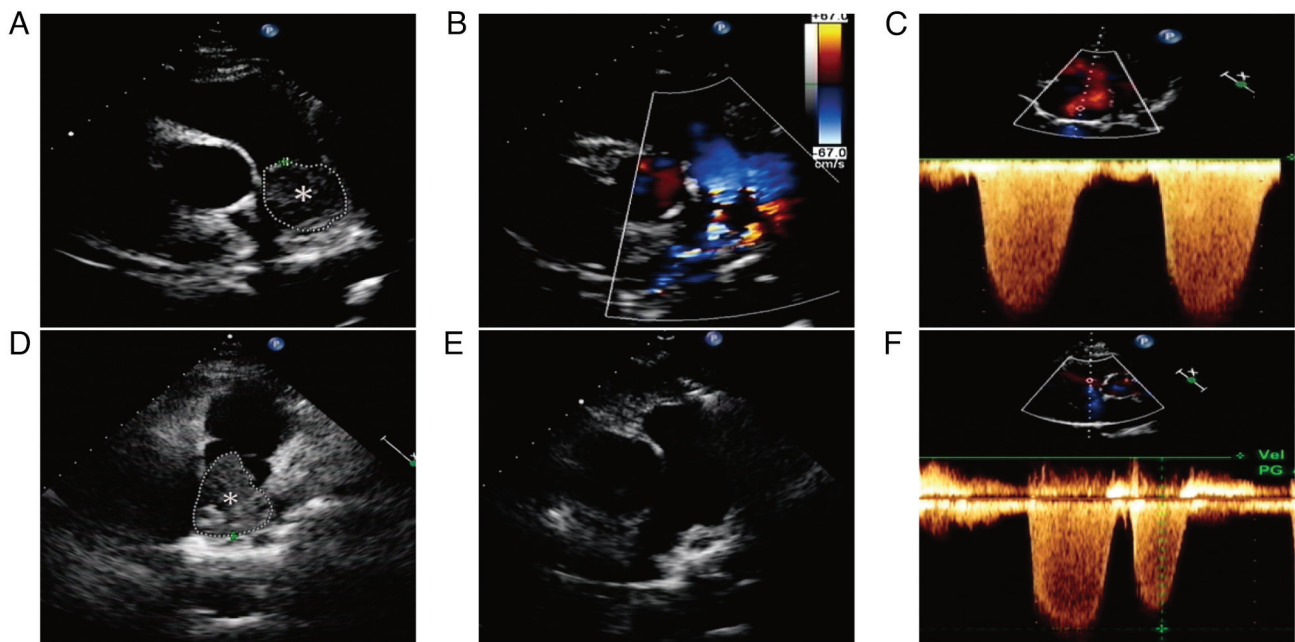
Transthoracic echocardiography results. (A) A large isoechoic mass (8.79 cm² in area) was found within the main pulmonary artery before admission, (B) with no blood flow detected in the mass. (C) Severe pulmonary hypertension estimated from tricuspid regurgitation. (D) The size of the isoechoic mass (11.4 cm²) in the main pulmonary artery after anticoagulant therapy had increased compared with its previous state. (E) No abnormal mass echo was detected in the pulmonary artery postoperatively and (F) mild pulmonary hypertension estimated from tricuspid regurgitation. Asterisks indicate the location of the lesion.
